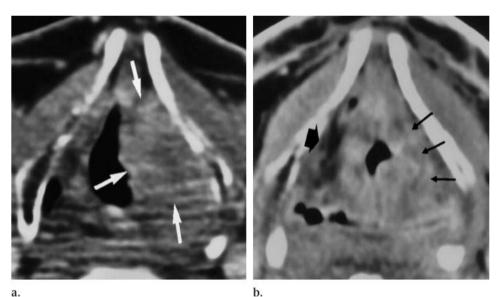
Axial CT images in a patient with T3 supraglottic carcinoma. (a) Pretreatment image shows a mass (arrows) in the region of the left false vocal cord and paraglottic space. (b) Image obtained 21/2 months after radiation therapy shows that the tumor has regressed but also shows persistent obliteration of the paraglottic fatty tissue (thin arrows) on the left side, without focal mass. Compare this with the normal-appearing paraglottic fat (thick arrow) on the right side there was no clinical evidence of disease.
